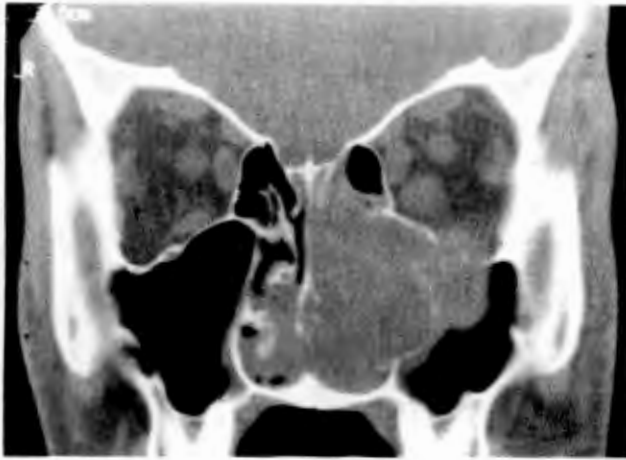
Coronal computed tomogram showing nasopharyngeal mass eroding through the left orbital floor. Pathology was consistent with juvenile nasopharyngeal angiofibroma.
